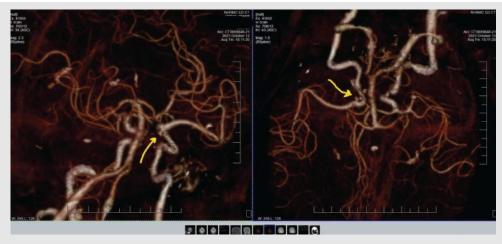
These CTA images of the patient described show two different rotational views of the carotid, vertebral and basilar arteries, along with distributions of the anterior and middle cerebral arteries. The yellow arrows are directing to the aneurysm at the junction of the internal carotid artery and posterior communicating artery, which is the source of the third nerve palsy.
